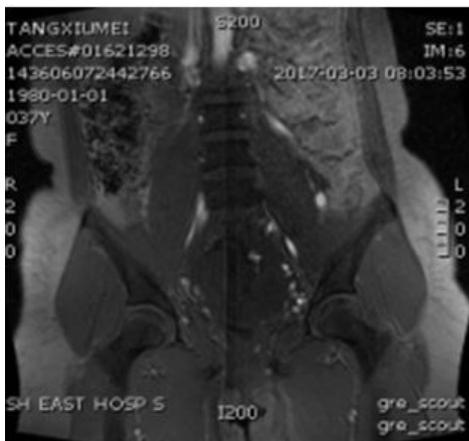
MRI showed complete placenta previa.
